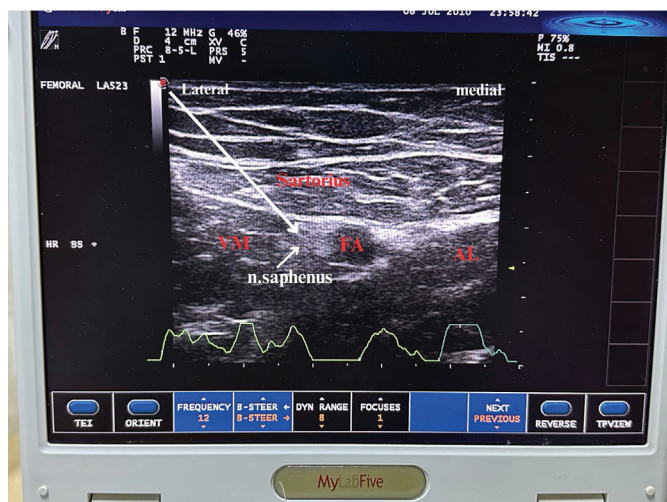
Ultrasound image of saphenous nerve block
